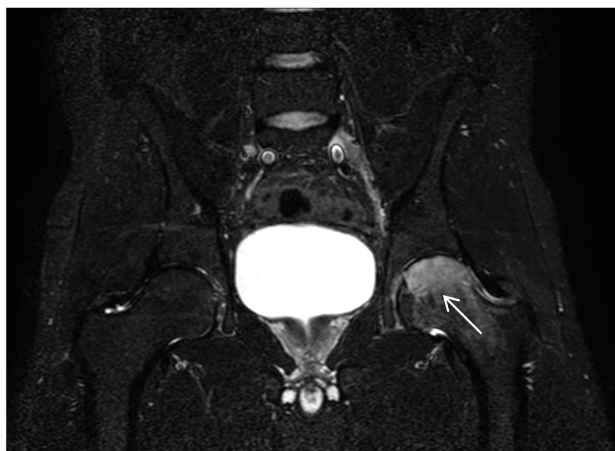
MRI images demonstrating excessive bone edema in the femoral head and neck as shown with arrow marks.
